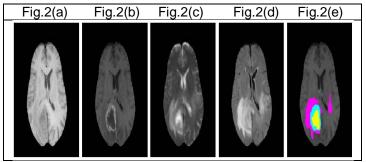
One axial slice of an MR image of a high-grade glioma patient. From left to right: T1-weighted image, T1weighted image with contrast enhancement, T2weightedimage, T2FLAIR-weighted image and manual segmentation into necrotic (yellow), active(green), edema (pink) tumor compartments. Necrosis and active tumor region were segmented based on the T1-weighted image with contrast enhancement, whereas the edema region was segmented based on the registered T2FLAIR-weighted image[13].
